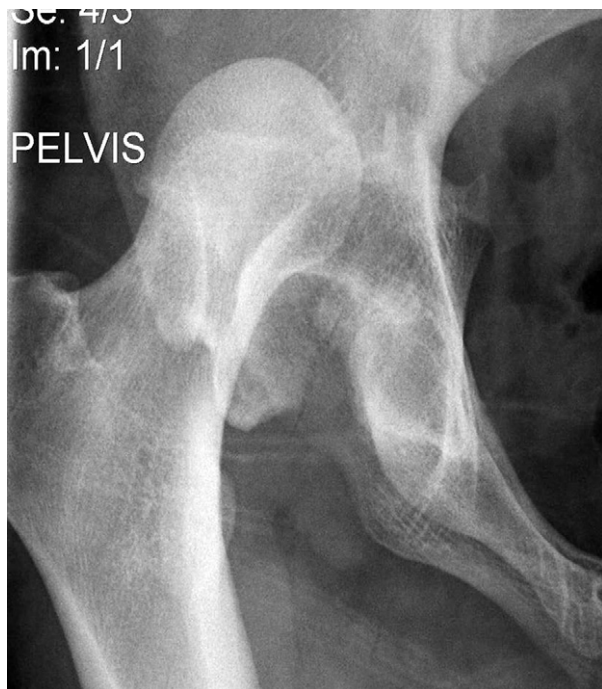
Anteroposterior pelvic radiograph showing hip dislocation following a traumatic injury.
